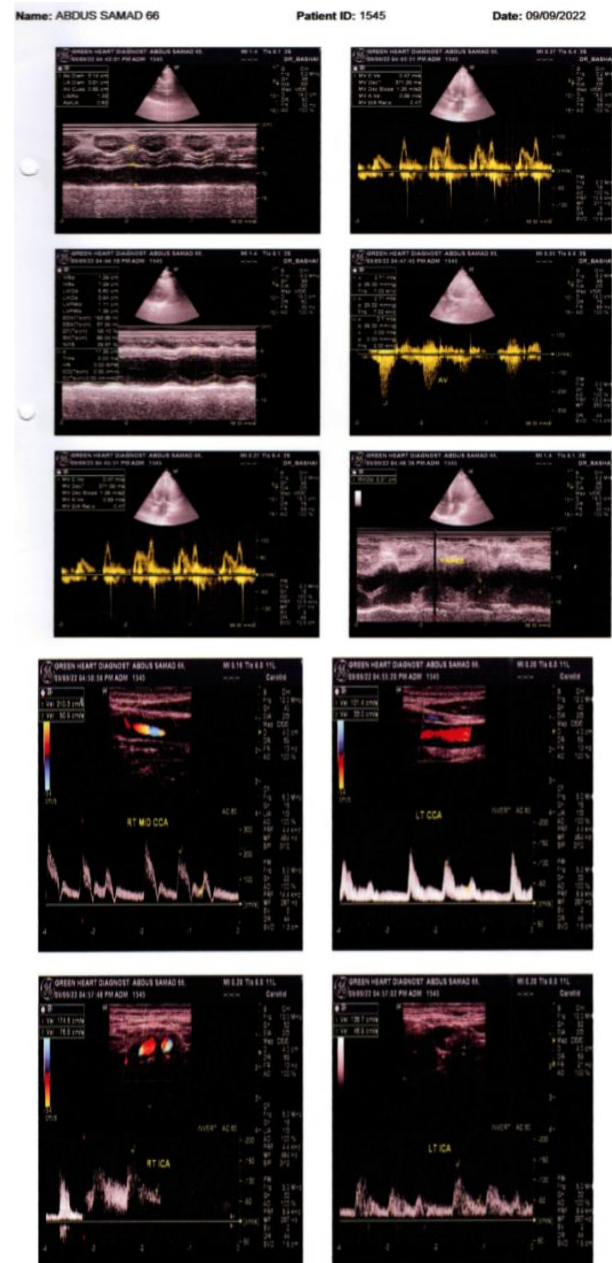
Echocardiography shows mild Aortic stenosis with EF 56%.
